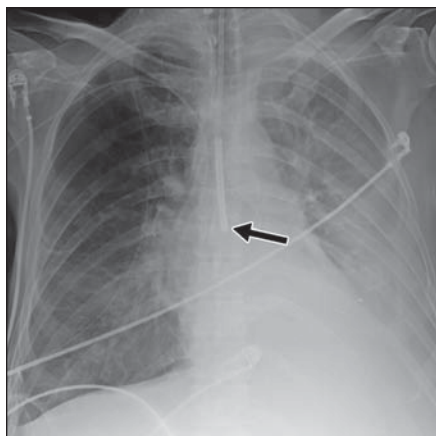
58-year-old man with incomplete insertion of feeding tube. Anteroposterior chest radiograph shows tip of feeding tube (*arrow*) projecting over mid esophagus. There is risk for aspiration pneumonia if feeding material is administered.
